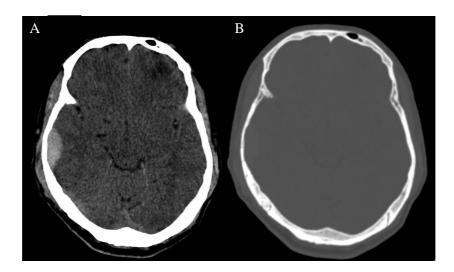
CT Brain plain study in a 28 years old male patient with history of Road traffic accident showing Extradural haemorrhage in right temporal region (A) and fracture of right temporal bone (B)
